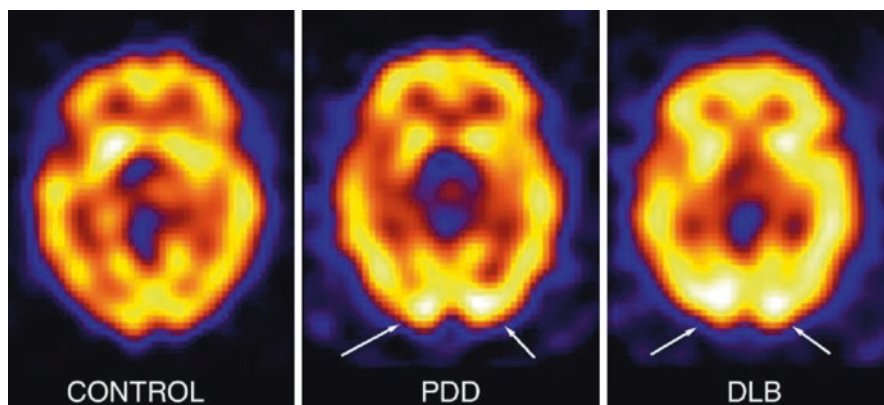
Representative axial ^{123}I -QNB SPECT scans of an individual control, PDD and DLB patients. Notice the significant upregulation of ^{123}I -QNB binding in PDD and DLB relative to the control in the lingual and inferior occipital gyri (arrows). (Reproduced from Colloby et al. 2006 with permission from Elsevier)
